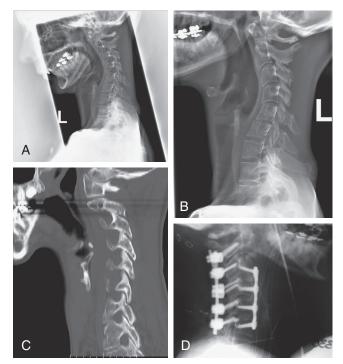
A, A 60-year-old woman with mechanical neck pain and cervical kyphosis 8 years after cervical laminectomy. B, Dynamic extension radiograph, showing that the kyphosis is inflexible. C, The CT scan demonstrates ankylosed joints. On MRI (not shown), there was no evidence of compression. The case was managed with a "540-degree" procedure starting dorsally to release the ankylosed joints and to place dorsal C2 pars and lateral mass screws. The patient was then placed into a supine position, and multilevel ventral interbody grafts were placed. Adjustment of intraoperative positioning was used to induce lordosis, and a lordotic ventral plate was placed. Intermediate points of fixation were also used to improve lordosis. The patient was then replaced in the prone position, and posterior rods were placed. D, The postoperative radiograph demonstrates that the patient had improved alignment, and clinically her mechanical neck pain and kyphosis improved.
